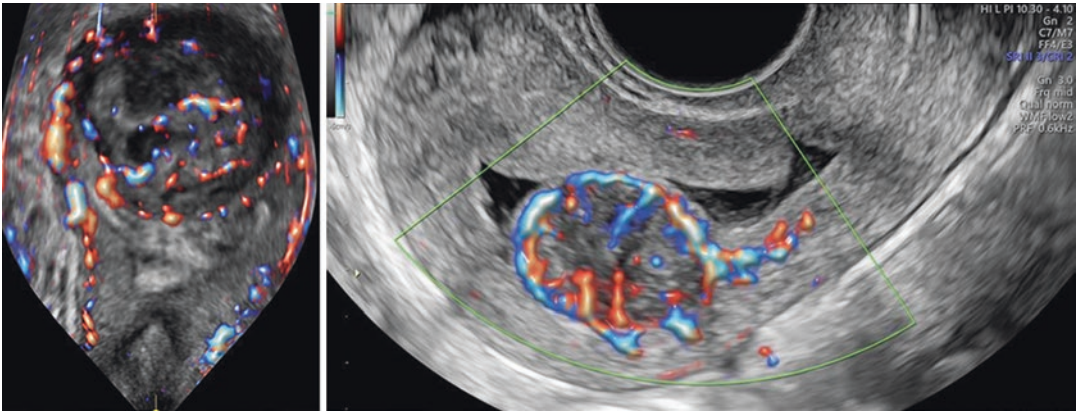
Color Doppler images of two patients presenting with a fibroid: on the left case (reconstructed 3D-polyline frontal section), the intramural fibroid in the fundus of the uterus shows subtle circumferential flow as
